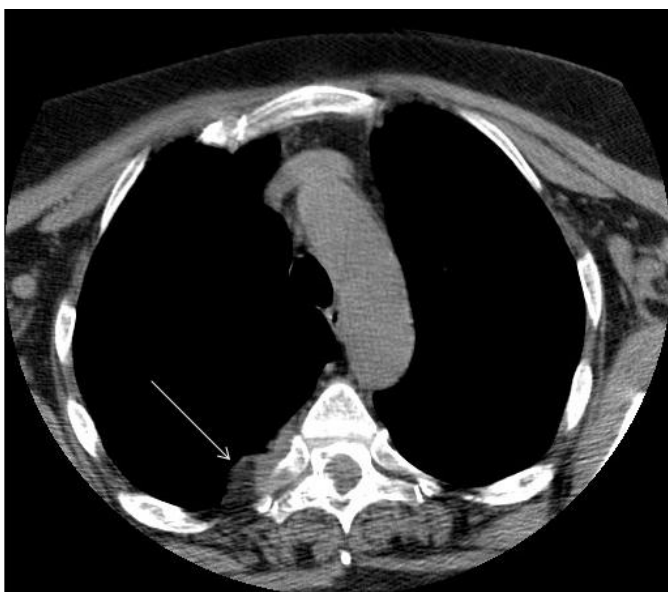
Unenhanced CT appearance of an angioliipoma in a 71 year old female. The inferior most image from a routine pre-thyroidectomy unenhanced axial image from a CT of the neck. It demonstrates a focal soft tissue density lesion in the right paravertebral pleural region with evidence of a discrete peripheral fat-density (white arrow). (Protocol: 120 kV, 45mAs, 2.5mm slice thickness).
